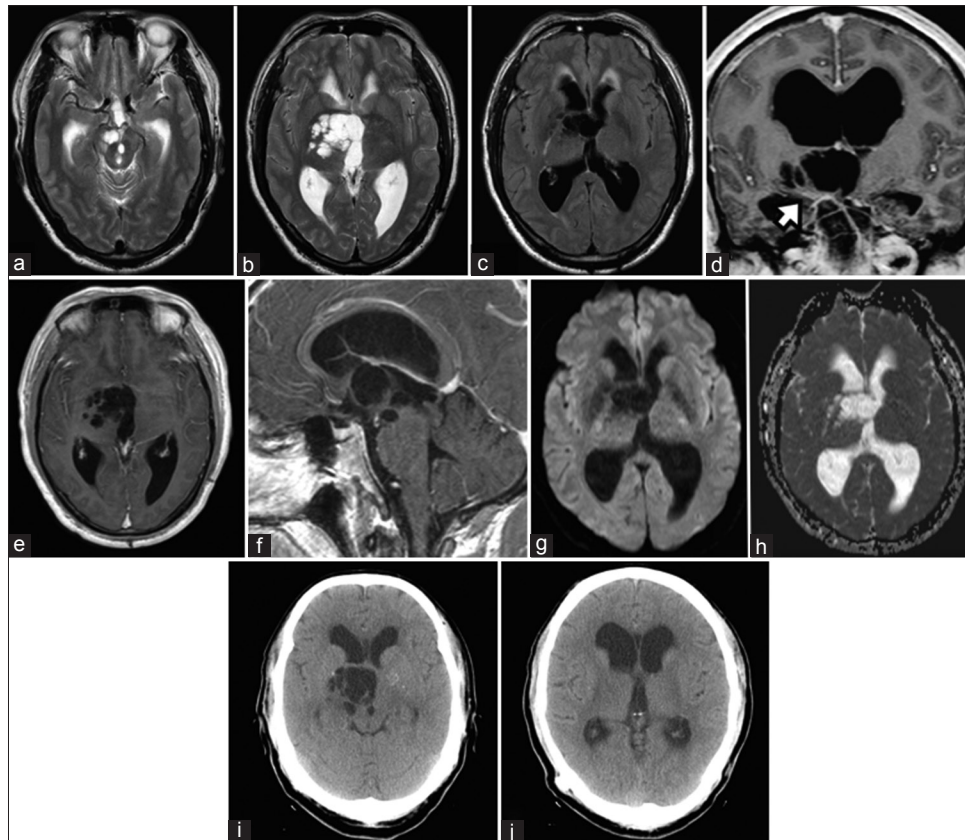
Multicystic perivascular spaces at the right cerebral peduncle of the midbrain that extended to the mesencephalon-diencephalon junction (a and b). Fluid-attenuation inversion recovery imaging revealed an absence of perilesional edema, but the presence of transependymal edema secondary to hydrocephalus (c). Thalamoperforating arteries as they coursed through the perivascular spaces (d, white arrow). The perivascular spaces did not display contrast enhancement (e and f). Diffusion weighted-imaging (g) and apparent diffusion coefficient (h) sequences showed that perivascular spaces fluid content had no restricted diffusion. One-year postoperative computed tomography scans showed no change in perivascular spaces (i) and ventricular size (j).
